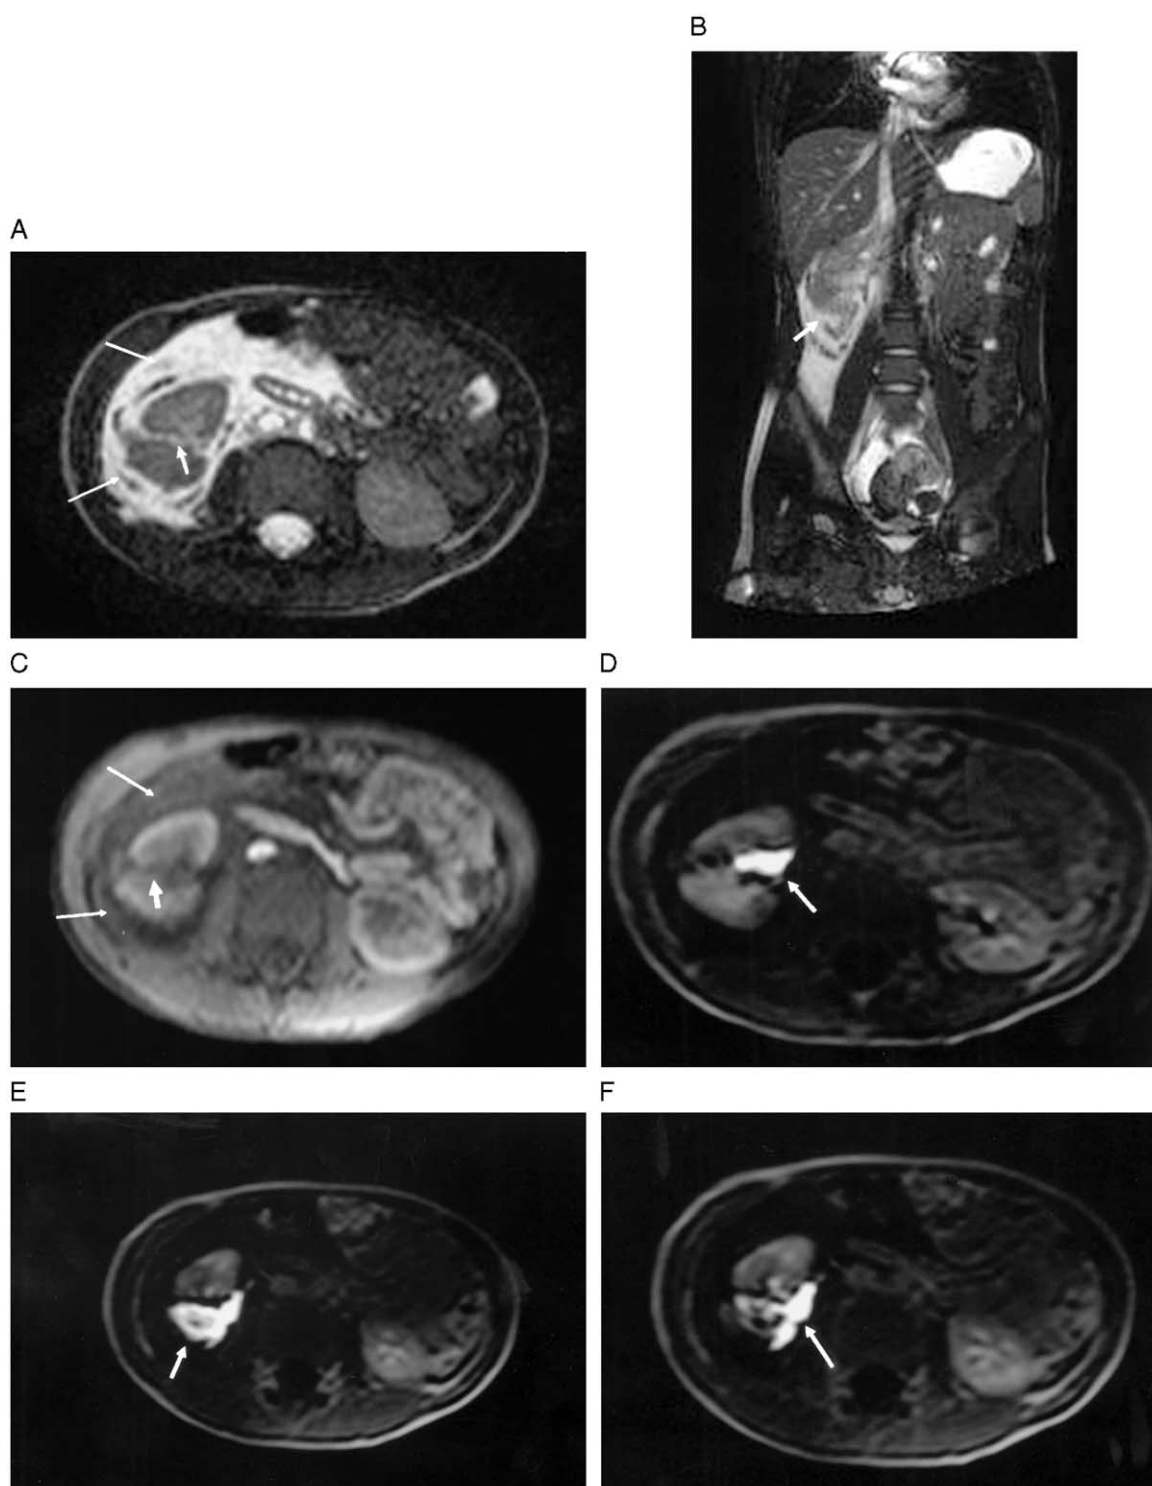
Renal laceration secondary to acute blunt abdominal trauma. Axial (A) and coronal (B) T2-weighted balanced fast field echo images (TR/TE/FA, 4.8/2.1/70) showing perinephric fluid with a hyper/hypointense mixed signal (thin long arrows, A) and the laceration site (thick arrows, A and B). (C) T1-weighted fat-saturated SGE image (TR/TE/FA, 167/4.2/80) showing perinephric fluid with a hyper/hypointense mixed signal compatible with a mixed acute and subacute hemorrhage (arrows, C). (D–F) Late enhanced T1-weighted SGE images (TR/TE/FA, 156/4.2/80) demonstrating contrast extravasation (arrows).
